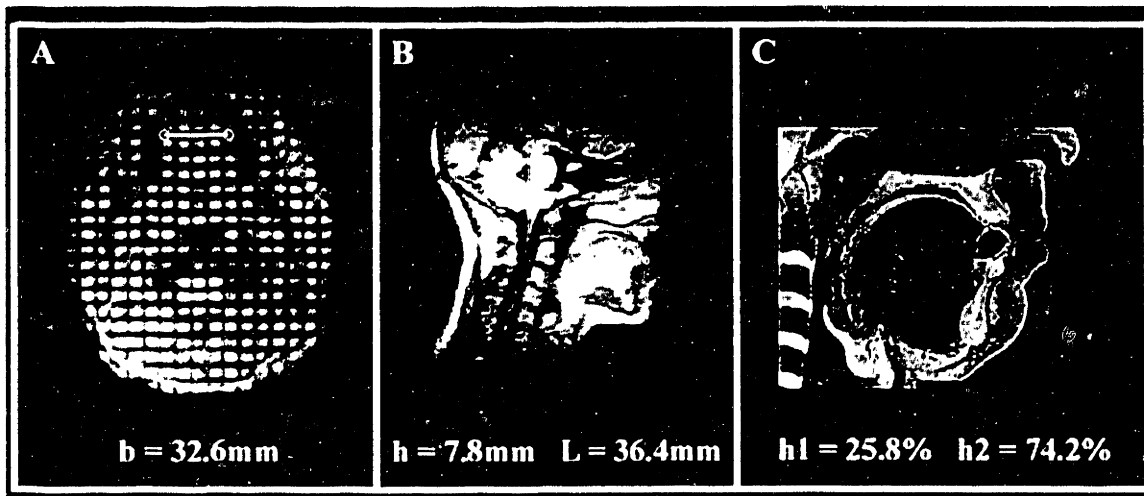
The spatial parameters used in the model were derived from either MRI images of the tongue, or from the Visible Human (Male) database. (A) Coronal view MRI image (with tag lines superimposed) of the tongue, depicting the width (b) of the tissue in the mid-anterior position, 32.6 mm. (B) Sagittal view MRI image of the tongue depicting the functional length (along its curvature) of the anterior tongue, 36.4 mm, and the cross-section height, h = 7.8 mm. (C) Sagittal view (cross-section) of the muscular structure of the anterior tongue, derived from the Visible Human database, showing the relative composition percentage of the longitudinal (25.8%) and transverse (74.2%) muscle layers.
